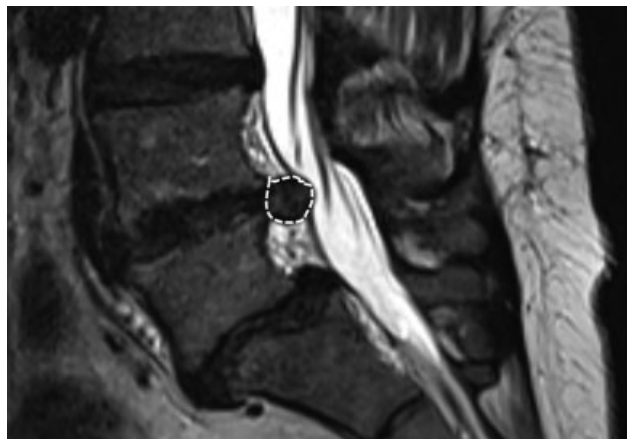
The sagittal slices of the T2-weighted sequences. A radiologist manually outlined the herniated disk in these slices.
